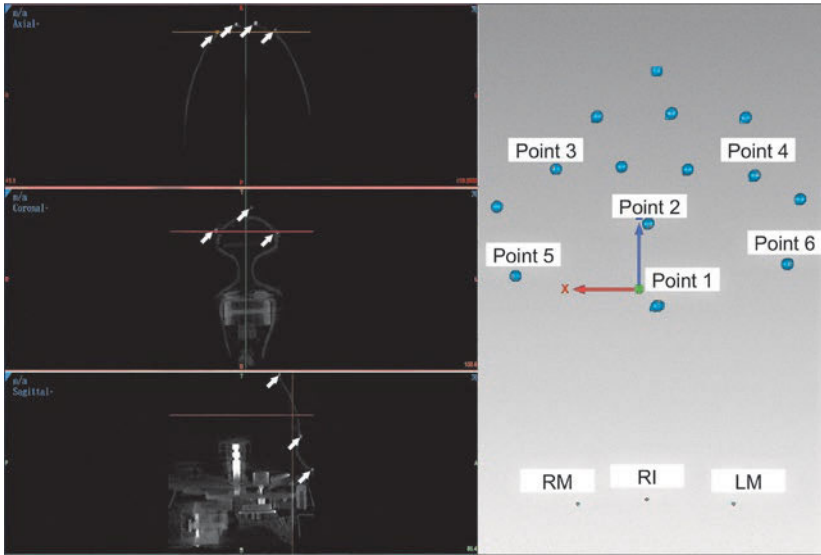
The feature points in the CBCT image of the mannequin head and the 3D reconstruction image.
